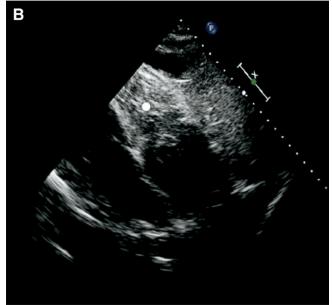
A*, Echocardiogram of patient on presentation. The asterick indicates pericardial effusion. The inverted arrow indicates right ventricle. *B*, Echocardiogram of patient after pericardicentesis. The circle indicates thrombus in right ventricle.
